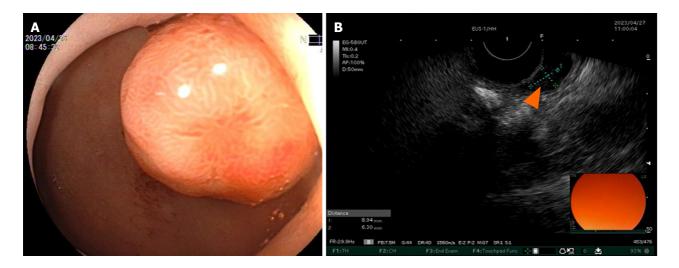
Gastroscopy and endoscopic ultrasonography. A: Gastroscopy findings of the mass; B: A slightly hypoechoic lesion with a broad base and approximately 8.9 mm × 6.3 mm is seen in the mucosal layer of the anterior wall of the duodenum (orange triangles).
